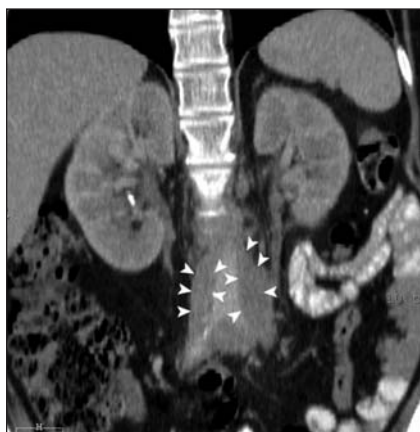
Computed tomography scan showing retroperitoneal mass (arrows).
